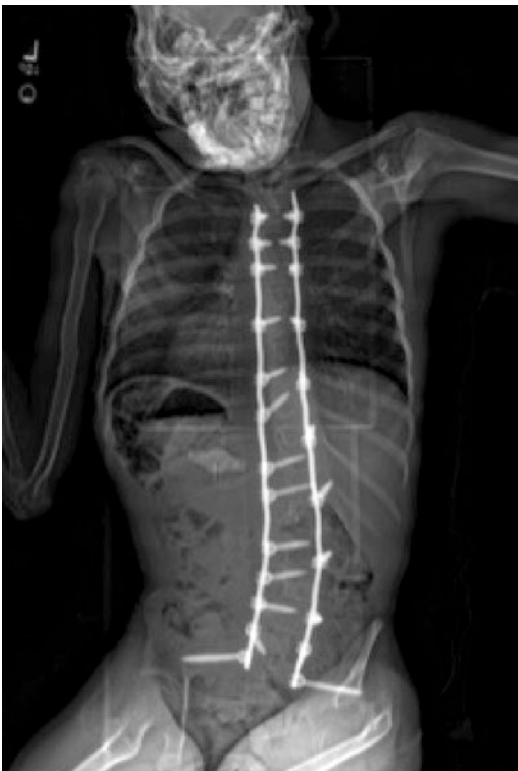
One-year postoperative radiograph after posterior spinal fusion with excellent improvement in deformity and improved seating balance
